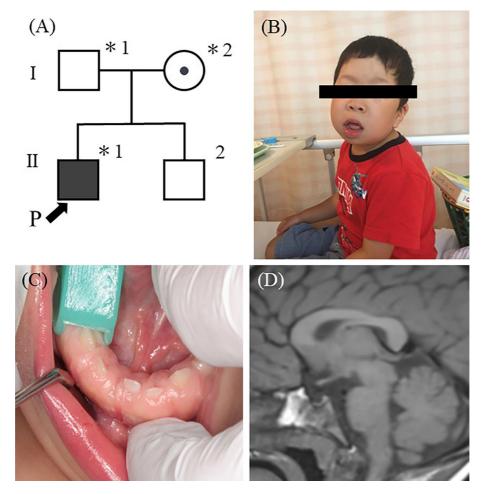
(A) Proband (II-1) family tree. The arrow (P) shows the proband, and asterisk (*) indicates the individual who received genetic testing. (B) The general appearance of the proband. Parental permission was obtained to publish the photograph. (C) Image of the oral findings of the patient, demonstrating gingival fibromatosis. (D) Magnetic resonance imaging of the brain and pituitary, showing pituitary hypoplasia and a thin pituitary stalk.
